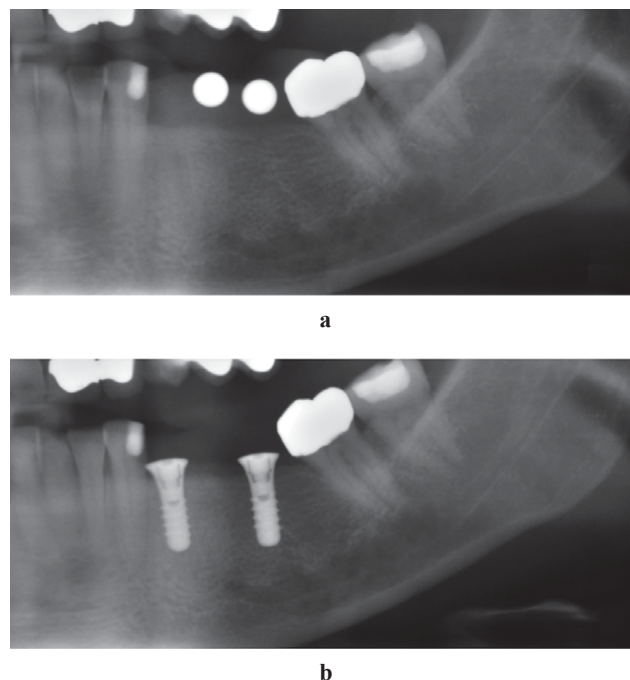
(a) Detail of a pre-operative panoramic radiograph shows two 5 mm diameter reference metal balls in the sites of a second premolar and a first mandibular molar. (b) Post-operative panoramic radiograph of the same patient shows two 10 mm long implants with small 1.5 mm high healing caps. To avoid risk of injury to the mandibular canal, the surgeon inserted an implant in the site of a first premolar and a first molar
